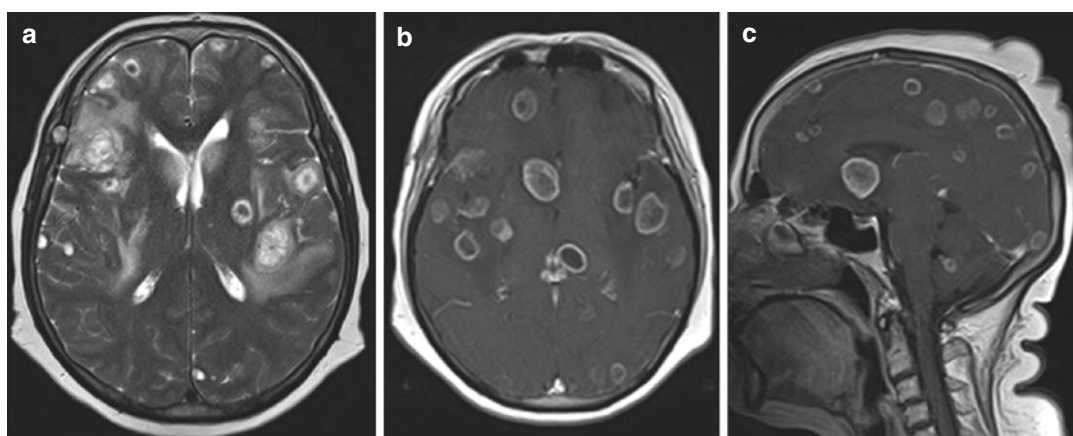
Multiple tuberculomas. (a) T2-weighted image through the lateral ventricles shows lesions with hypointense core and peripheral hyperintensity in bilateral frontotemporal regions. Axial (b) and sagittal (c)
